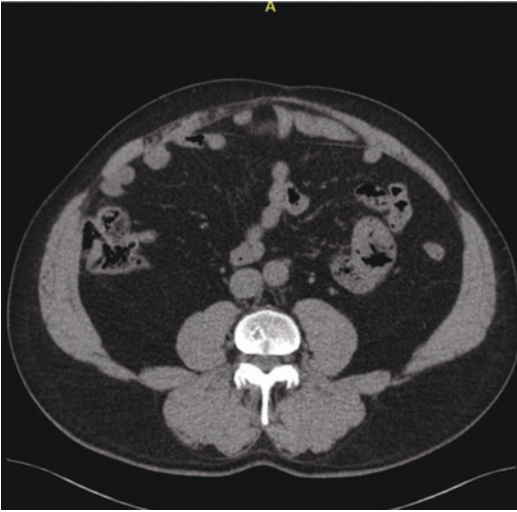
Posterior sheath breakdown on computed tomography
